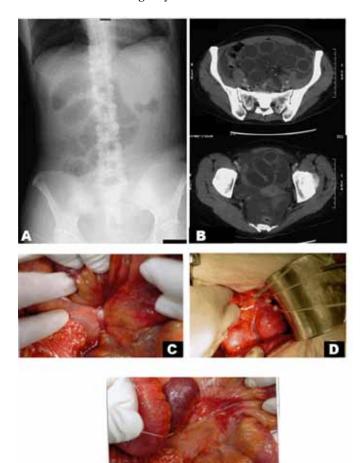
(A, B) The X-ray and computed tomography (CT) scan were taken four days later. X-ray showing an increase in the small intestinal gas. Computed tomography scan showing the distended loops with air-fluid level in the Douglas' pouch. Mesenteries and blood vessels concentrate in the vicinity of uterus. The distended loops push the uterus to contralateral and ventral side. In addition, the loops push the sigmoid colon and rectum to the back side, (C) The mesentery was tightened by the Fallopian tube, (D) The situation after dissection of the fallopian tube and ligament of ovary, (E) The mesentery congested with blood.
